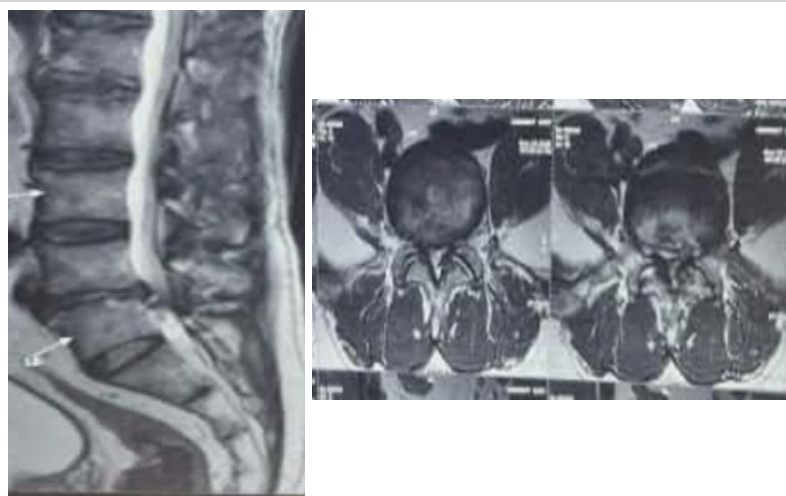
Magnetic resonance imaging (T2) Sagittal and axial cut shows central canal stenosis with bilateral lateral recess stenosis, with right lateral prolapse intervertebral disk.
